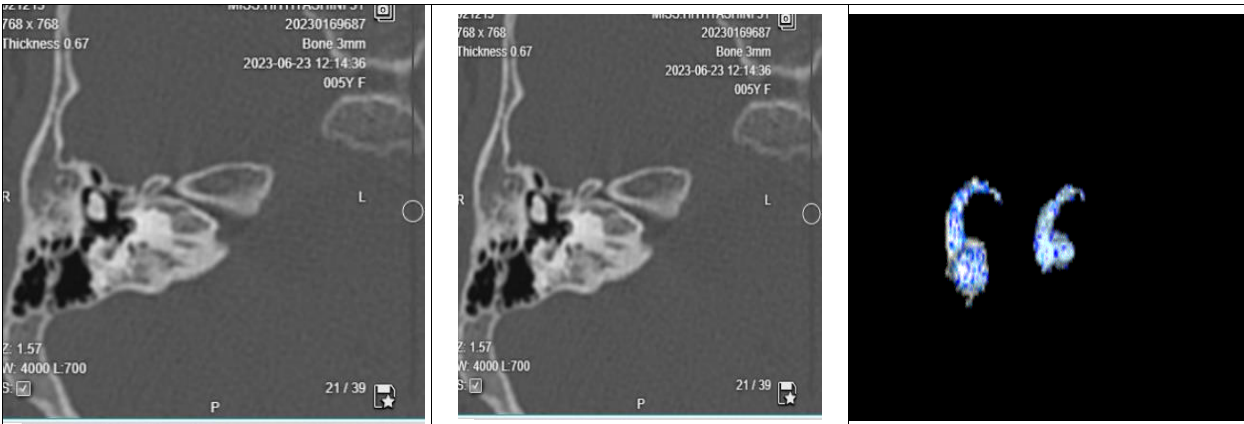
HRCT showing complete cochlear aplasia with stenotic Internal auditory canal. 3 D image showing hypoplastic vestibular apparatus with absent cochlea
